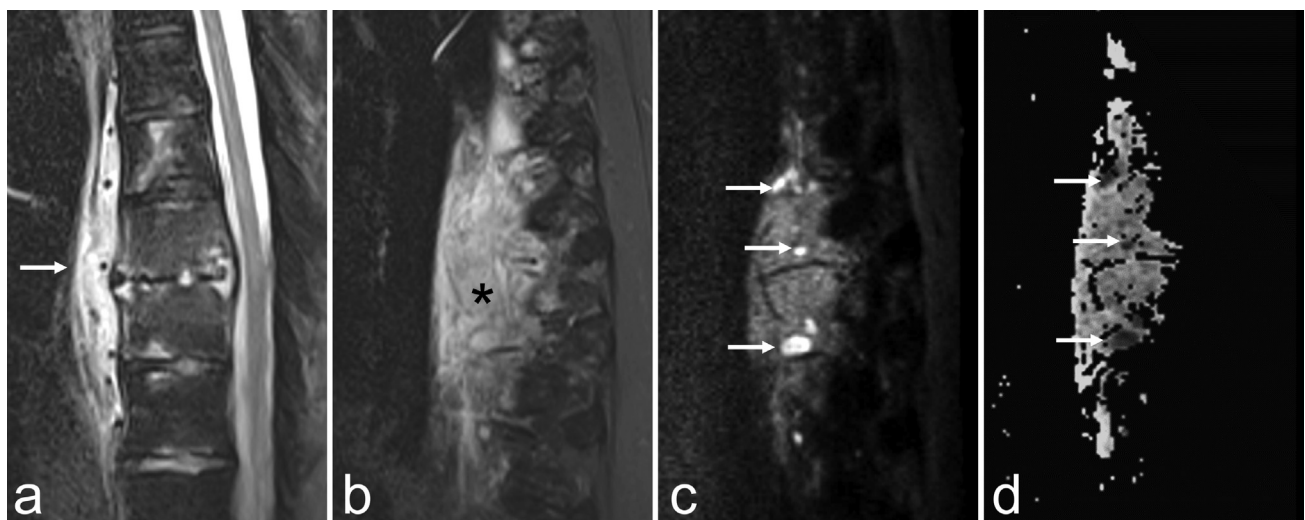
A 29-year-old man with pyogenic spondylodiskitis. (a) Sagittal fat-suppressed T2-weighted image shows T8–T9 spondylodiskitis with a spread of the infection to the prevertebral soft tissues (arrow). Sagittal left paramedian (b) fat-suppressed T2-weighted diffusion-weighted image (DWI) ($b = 700$) and apparent diffusion coefficient map show a phlegmon involving the paravertebral soft tissues (asterisk) with areas of restricted diffusion (c, d, arrows) corresponding to (micro)abscesses. DWI can be useful to detect soft tissue abscesses if intravenous contrast injection is contraindicated.
